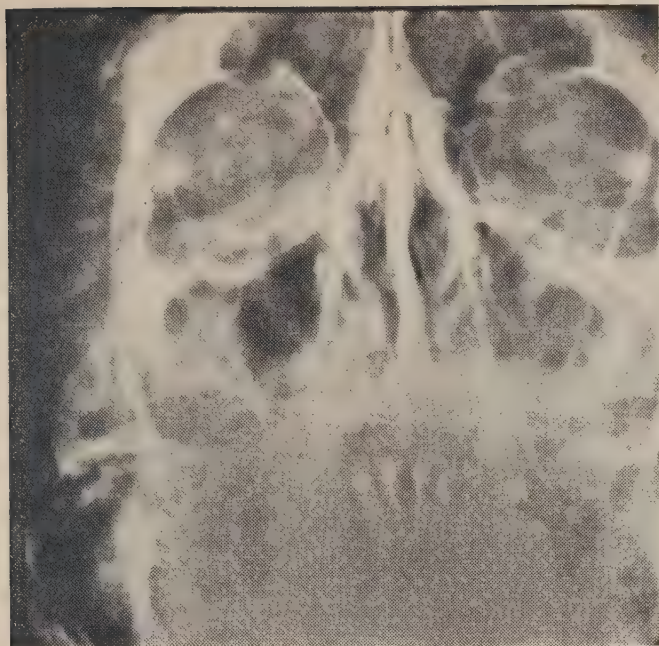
Water's projection radiograph showing clouding of left maxillary sinus.
